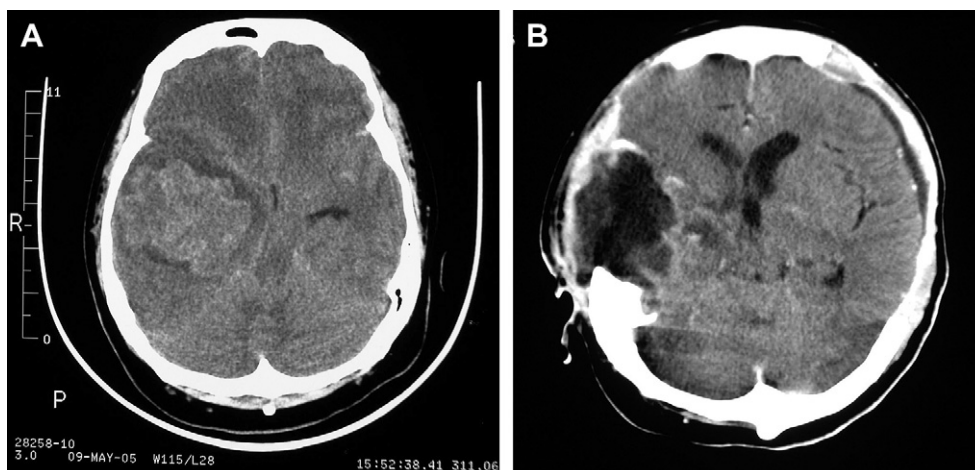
(A) Brain CT showing right temporal mass with perifocal edema and uncal herniation. (B) Repeat CT 2 weeks after surgery.
